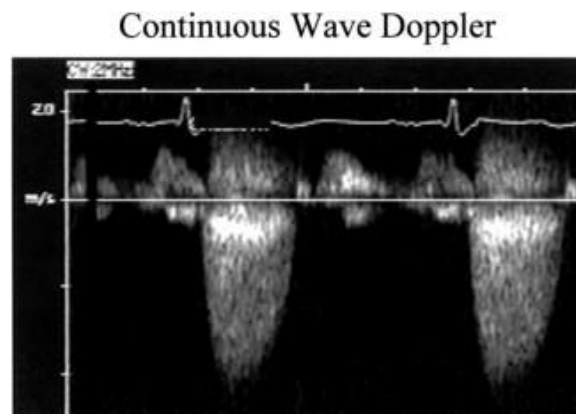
CW Doppler recording of velocity through aortic valve in patient with AS. Transducer position is at apex; thus systolic velocities are displayed below baseline. In diastole, positive mitral inflow velocities can be seen as inflow moves toward transducer. Note wide spectral dispersion of velocities during systole and diastole indicating that Doppler beam is detecting all flow velocities encountered along its course.
